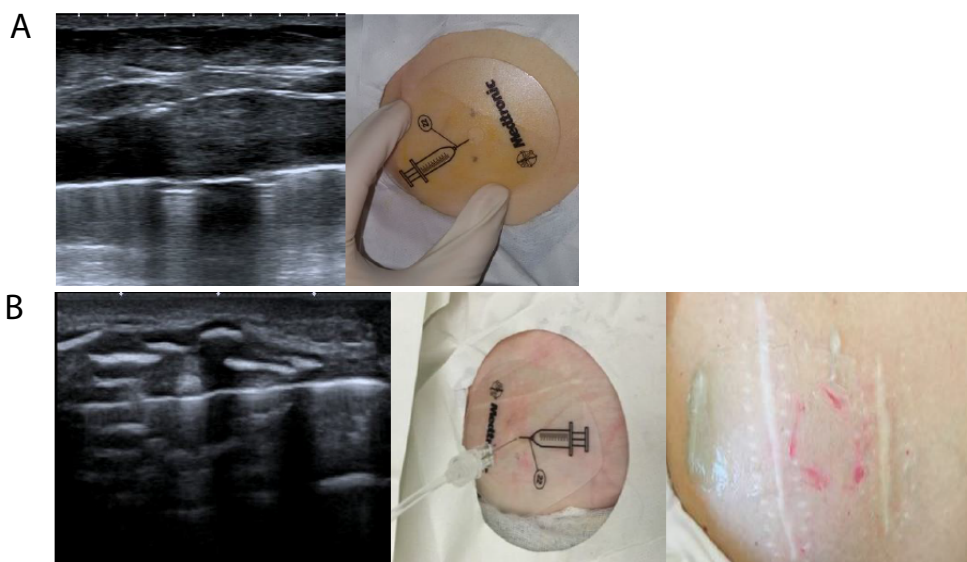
A) Case one: US imaging of ITB, surface of the intrathecal pump identified by a well-defined hyperechoic line with acoustic shadowing deep to this line with the shadows of the hole with the membrane. The distance between the skin and the pump was of less than 1cm; Photo pf Belly: Access port of the pump showed with the guidance of the refill template, black spots (marked on the bilateral side of the ultrasonic probe) identified with US completely match with the access of the pump. B) Case two: US imaging of ITB, surface of the intrathecal pump identified by a well-defined hyperechoic line with acoustic shadowing deep to this line with the shadows of the hole with the membrane. The dysomogeneous hyperdense tissue on the surface of the pump characterize the big scars and fat layer. Photo pf Belly: Access port of the pump showed with the guidance of the refill template, black spots (marked on the bilateral side of the ultrasonic probe) identified with US completely match with the access of the pump, cutaneous scars and fat layer.
